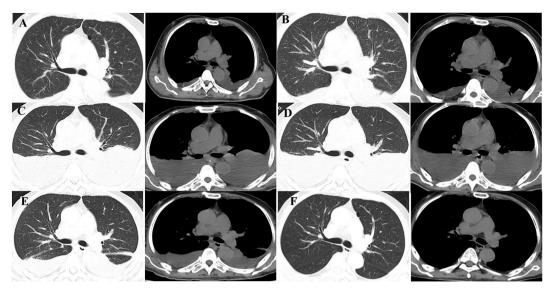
Chest CT image. (A) Minor pleural effusion with partial atelectasis of both lower lungs on July 3, 2021. (B) Minor pleural effusion with partial atelectasis of both lower lungs on July 17, 2021. (C) Massive pleural effusion with partial atelectasis of both lower lungs on July 30, 2021. (D) Massive pleural effusion with partial atelectasis of both lower lungs on August 7, 2021. (E) Massive pleural effusion with partial atelectasis of both lower lungs on August 30, 2021. (F) The pleural effusion significantly decreased compared to that before on October 3, 2021.
